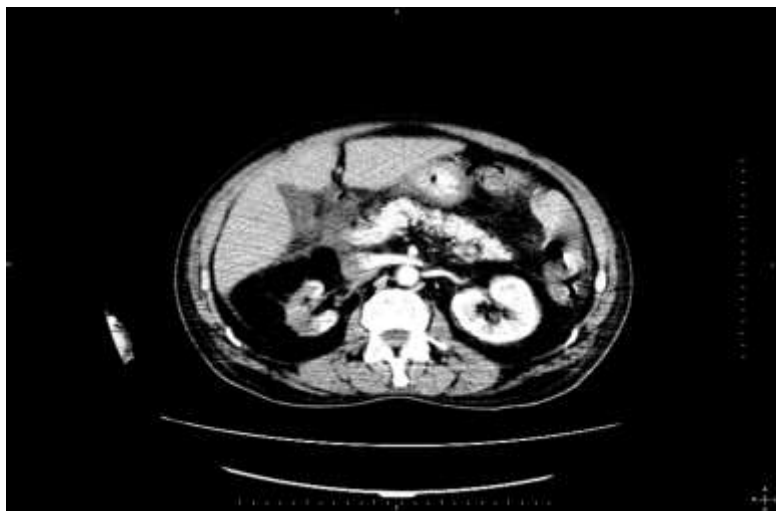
The right kidney was small sized while the left kidney dimensions were normal. Main renal artery and its branches sized smaller compared to left ones. CT demonstrated hypodense, non-enhanced corticomedullary areas in the middle one-third of right kidney. Some of the affected zone were seen as wide-wedge shaped, clearly demarcated areas while other areas were seen as ill defined, focal, peripherally located hypodensities.
